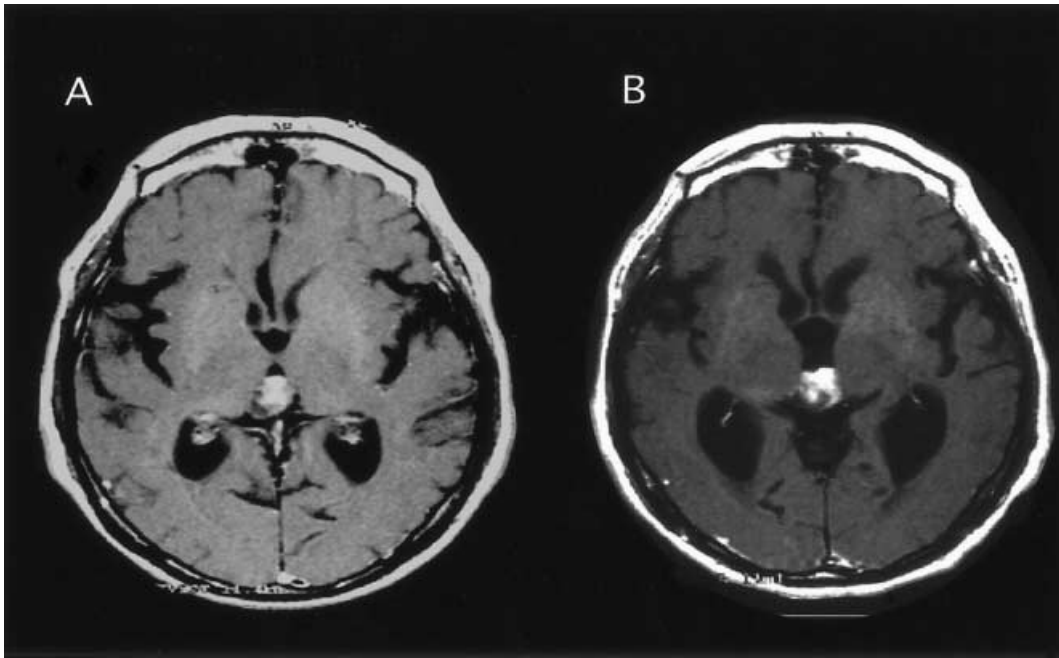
Magnetic resonance images in February 1996 at the age of 69 (A) and in January 1998 when the obstructive hydrocephalus was noted (B). However, the size of the tumour remained almost unchanged
